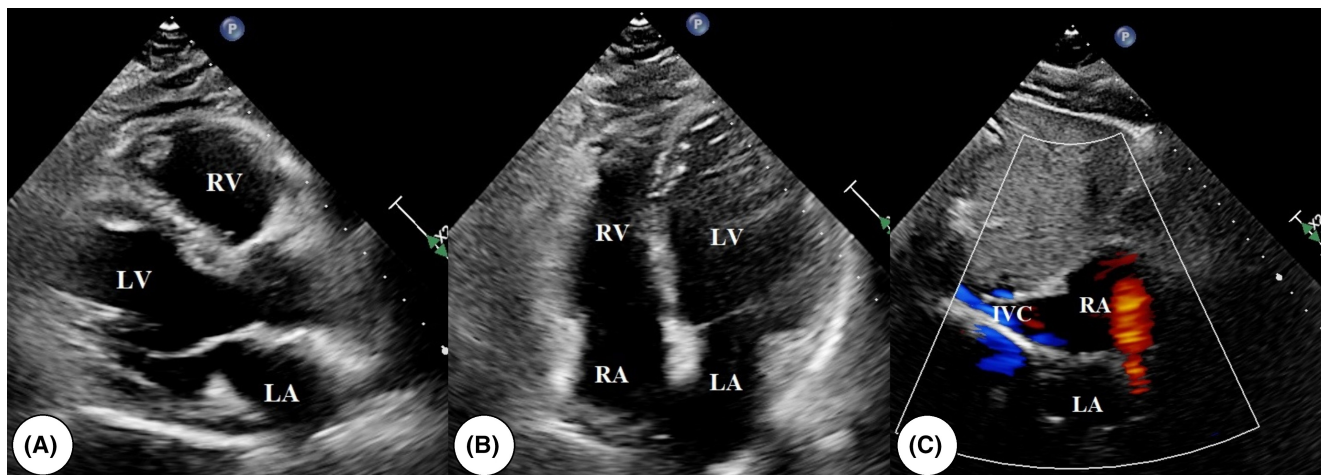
Transthoracic echocardiography images. (A) Parasternal long-axis view of the LV. (B) Apical four-chamber view of the heart. (C) Section image of subxiphoid section of both atria. IVC, inferior vena cava; LA, left atrium; LV, left ventricle; RA, right atrium; RV, right ventricle.
